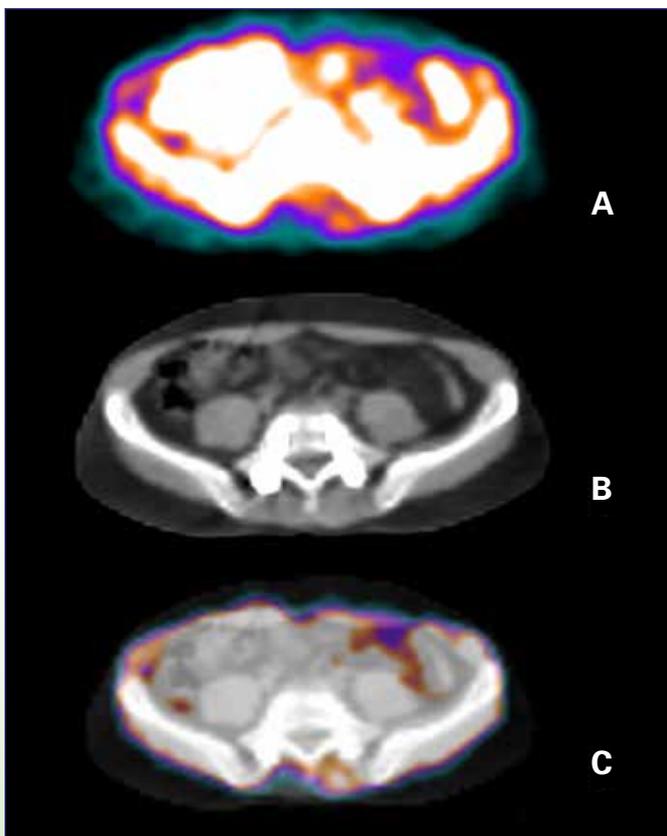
An example of decreased  $^{99m}\text{Tc}$ -sestamibi uptake in paraspinal muscles; transaxial SPECT (A), CT (B) and fusion SPECT/CT (C) images obtained after standard exercises show decreased uptake in paraspinal muscles on the right side.
